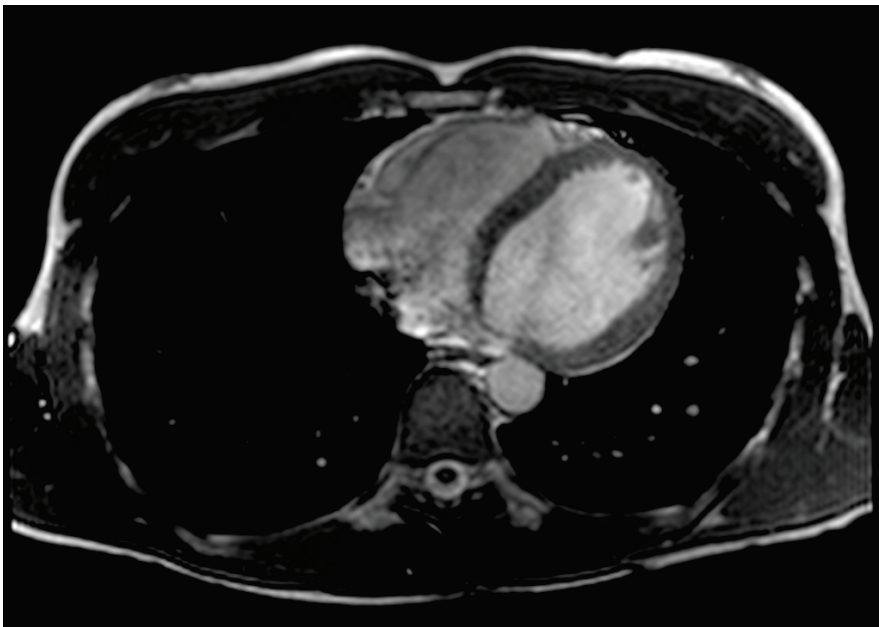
An MRI image of a male human chest. The image is a horizontal slice of the chest approximately at the middle of the heart, viewed from the bottom and up. The front of the person is facing up in the figure. The large grey area slightly to the left in the thorax (to the right in the picture) is the heart. The large dark areas are the lungs.
